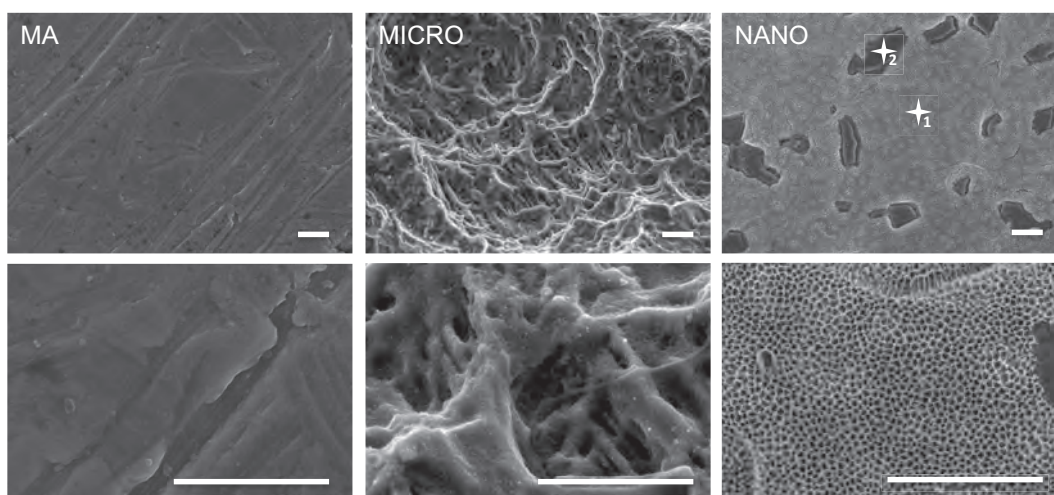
FE-SEM images of the three types of titanium surface: machined (MA), alumina grit-blasted and acid-etched (MICRO) and nanostructured (NANO) (magnifications $\times 10000$ and $\times 50000$, scale bar: $1\ \mu\text{m}$). Stars indicate the X-ray analysis on the NANO surface.
